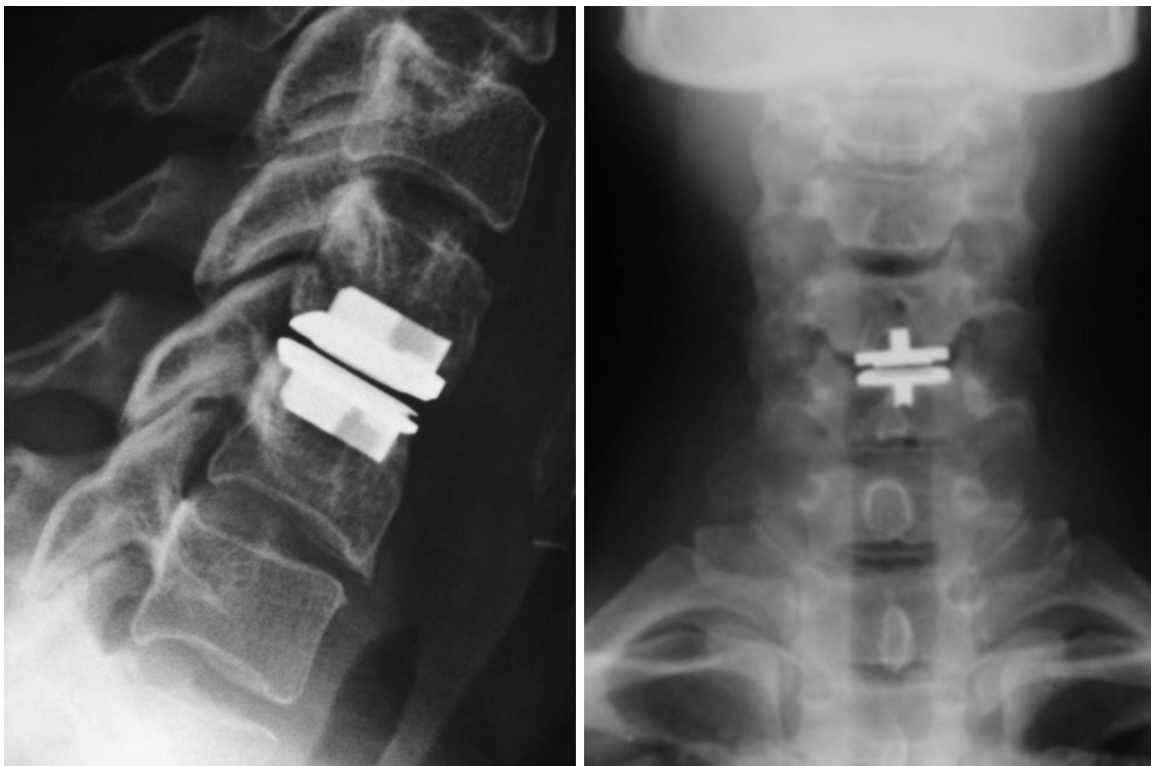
AP and lateral radiographs of a ProDisc-C
